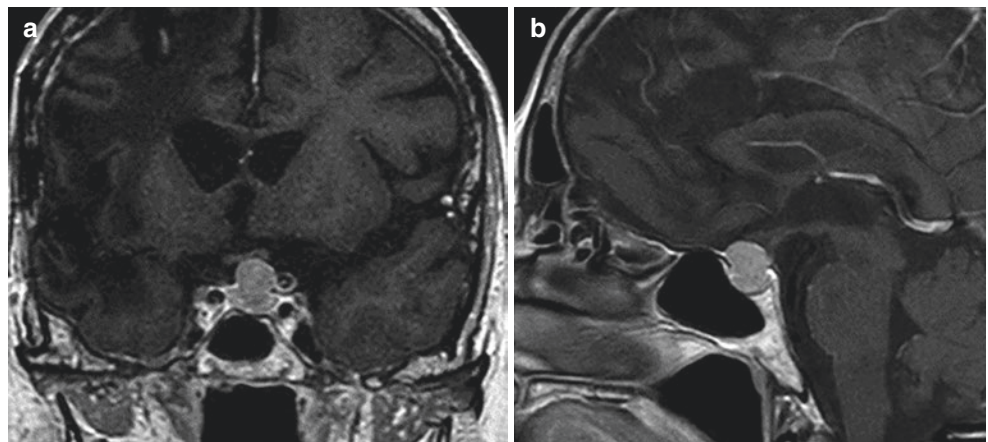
Coronal (a) and sagittal (b) preoperative MRI scan with contrast enhancement showing a tuberculoma sellae meningioma. (b) Post operative sagittal MRI scan confirming gross total resection of the tumor
